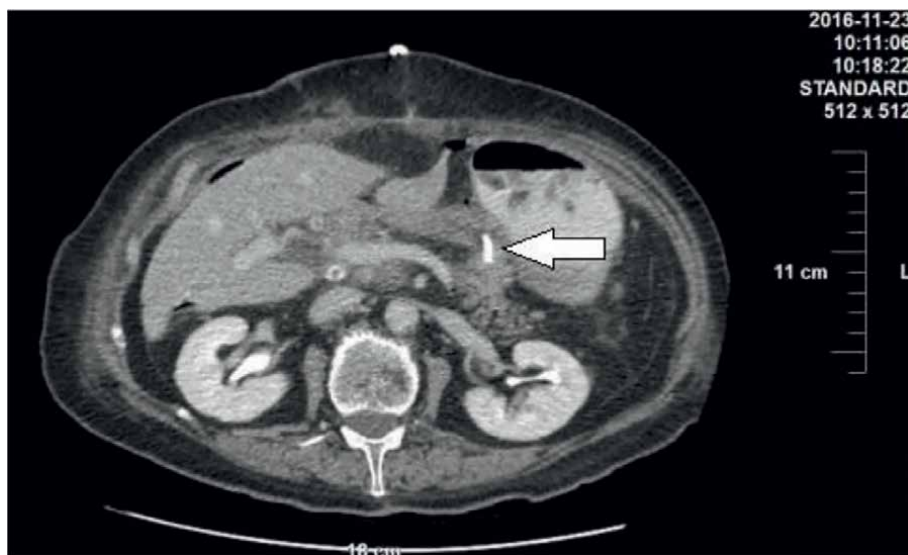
Pancreaticoduodenectomy. Postoperative computed tomography showing pancreaticojejunal anastomosis with covered coronary artery stent (arrow) in place [original photograph].*
